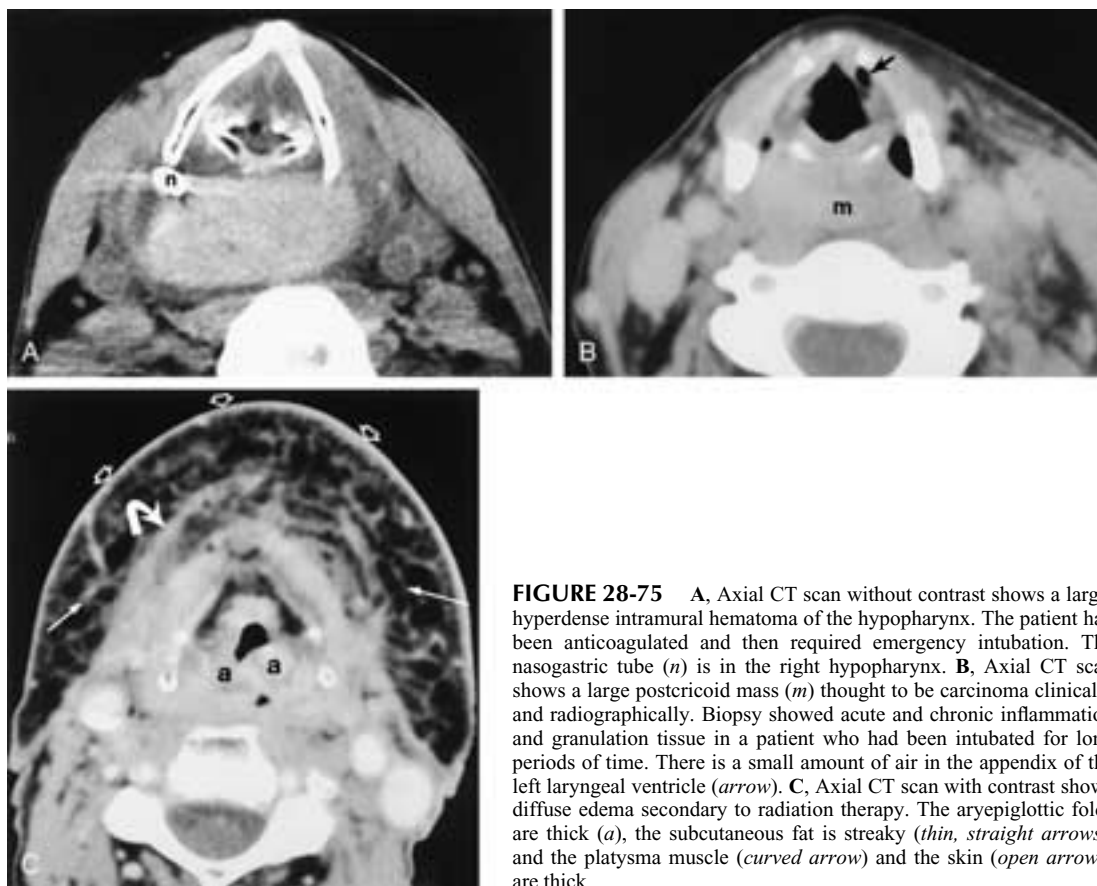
A, Axial CT scan without contrast shows a large, hyperdense intramural hematoma of the hypopharynx. The patient had been anticoagulated and then required emergency intubation. The nasogastric tube (*n*) is in the right hypopharynx. B, Axial CT scan shows a large postcricoid mass (*m*) thought to be carcinoma clinically and radiographically. Biopsy showed acute and chronic inflammation and granulation tissue in a patient who had been intubated for long periods of time. There is a small amount of air in the appendix of the left laryngeal ventricle (*arrow*). C, Axial CT scan with contrast shows diffuse edema secondary to radiation therapy. The aryepiglottic folds are thick (*a*), the subcutaneous fat is streaky (*thin, straight arrows*), and the platysma muscle (*curved arrow*) and the skin (*open arrows*) are thick.
